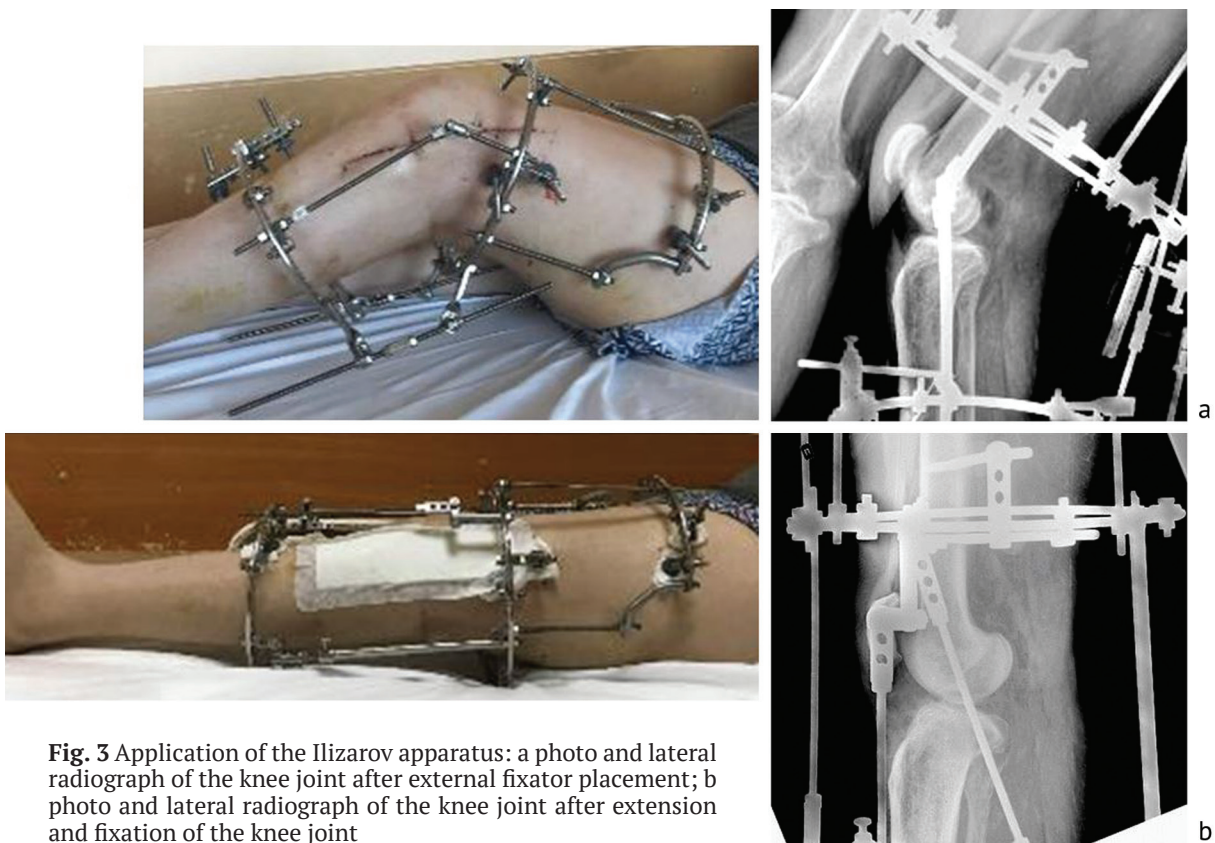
Application of the Ilizarov apparatus: a photo and lateral radiograph of the knee joint after external fixator placement; b photo and lateral radiograph of the knee joint after extension and fixation of the knee joint
